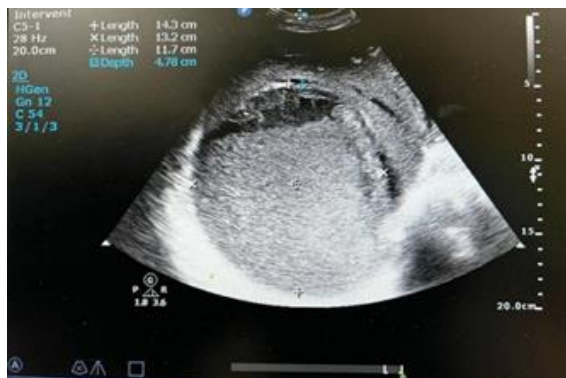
Ultrasound to assess the volume.
